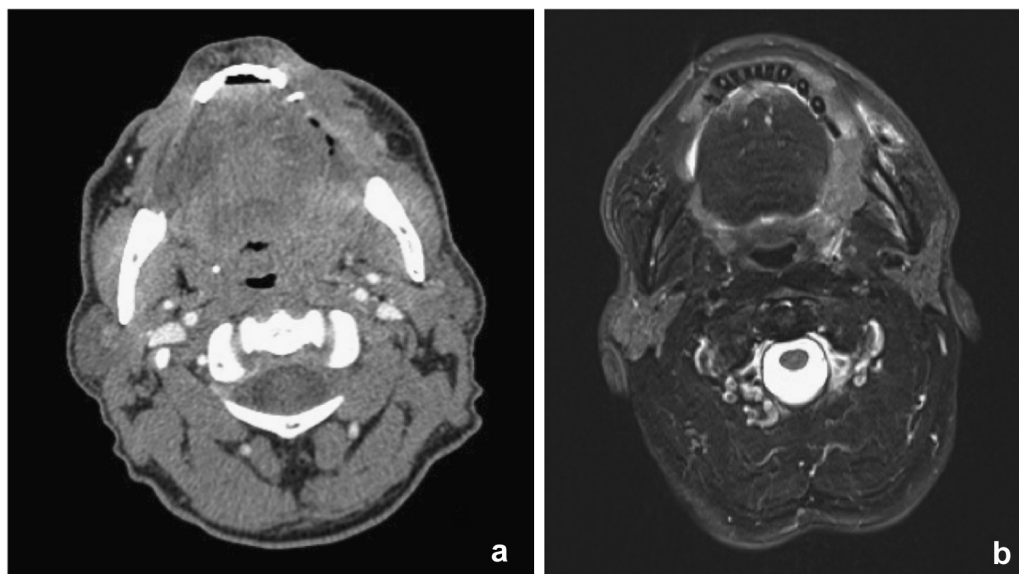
Left oropharyngeal/buccal squamous cell carcinoma on (a) contrast-enhanced computed tomography and (b) T2 axial DIXON-FS magnetic resonance imaging (MRI), showing the benefits of superior contrast resolution in MRI.
